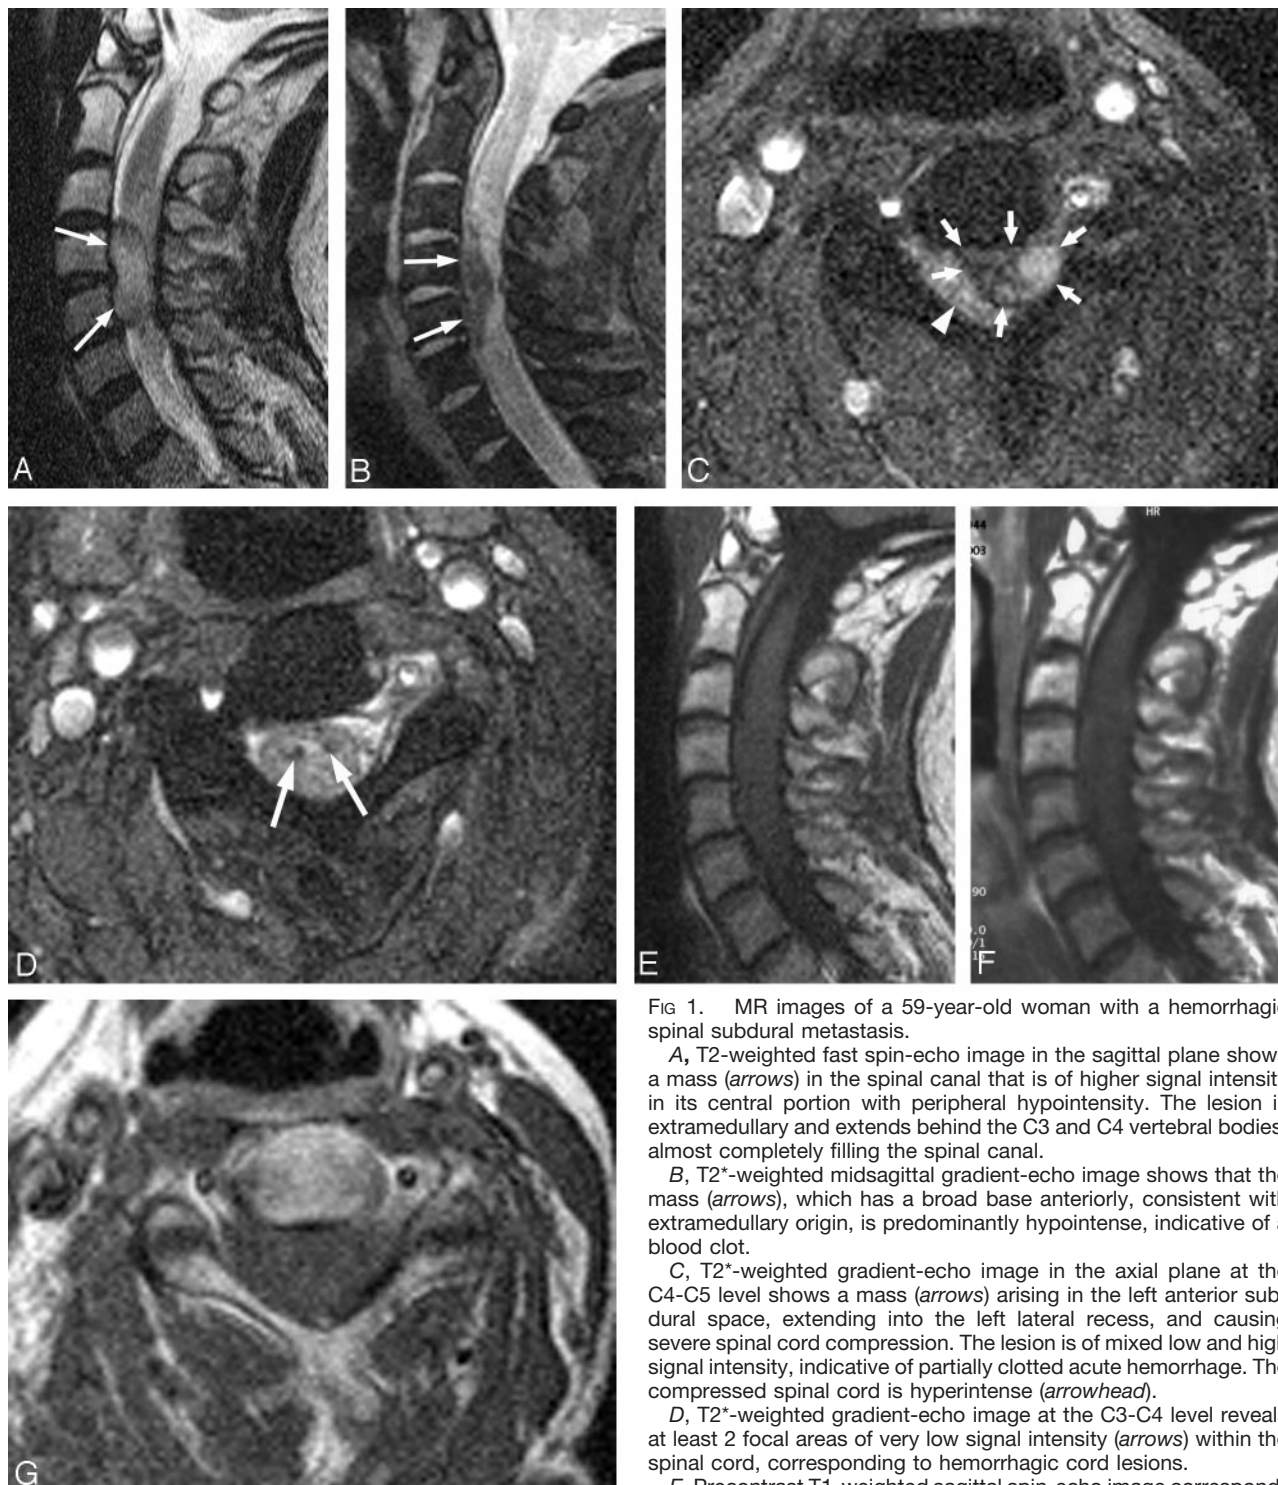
MR images of a 59-year-old woman with a hemorrhagic spinal subdural metastasis.
